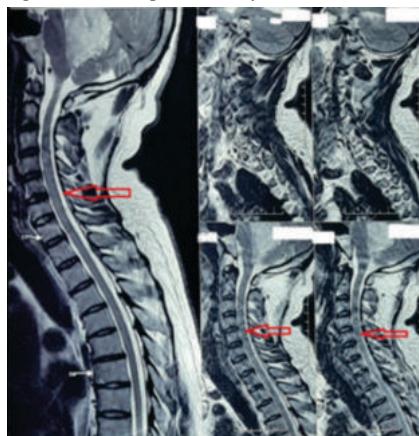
MRI Cervical Spine.
